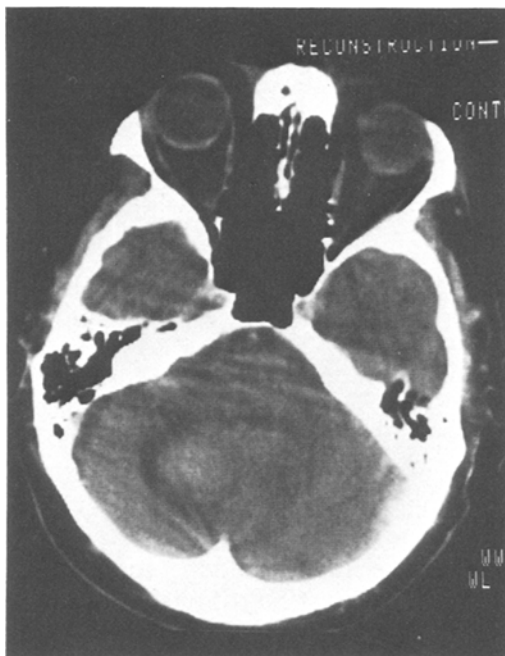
b. *Case 2*: CT scan after two weeks. Partial resolution of the cerebellar haemorrhage
